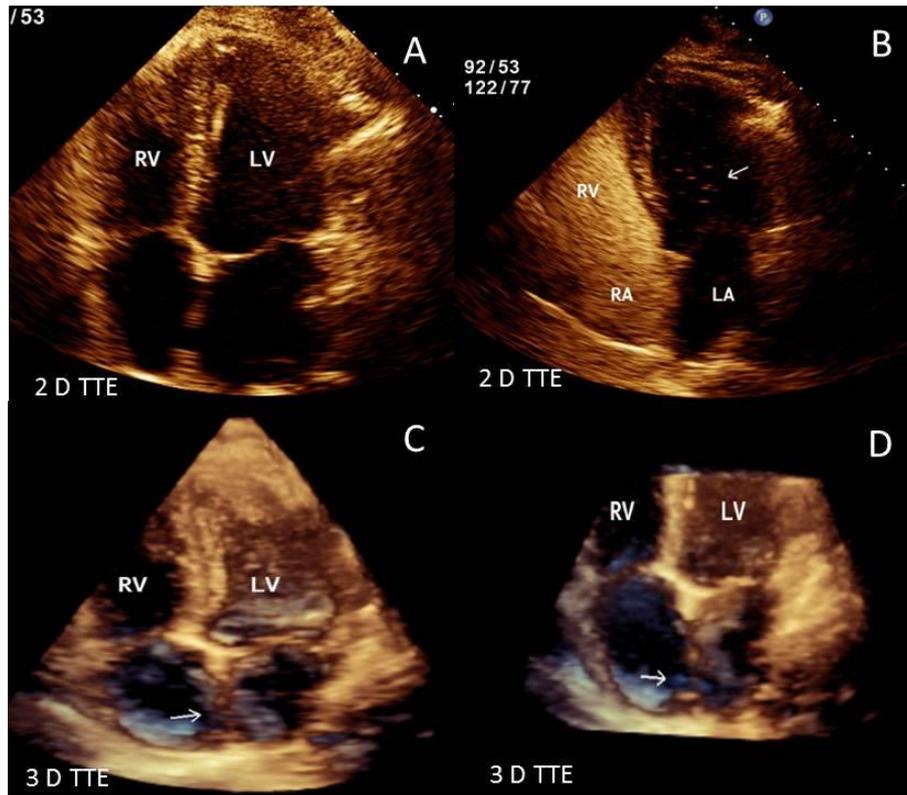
A 51 year old male with saddle pulmonary embolus and impending paradoxical embolism. Transthoracic echocardiographic (TTE) images are shown. Findings: A. Parasternal short axis view showing a severely dilated right ventricle (RV) severely compressing and deforming the left ventricle (LV) into a D shape due to marked deformity of the interventricular septum during late systolic and throughout diastole indicative of severe right ventricular pressure and volume overload.
